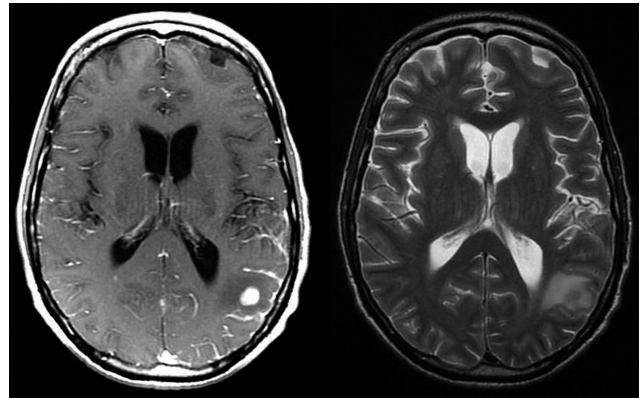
MRI of the brain showing an enhancing left parietal nodule along with diffuse meningeal enhancement.
